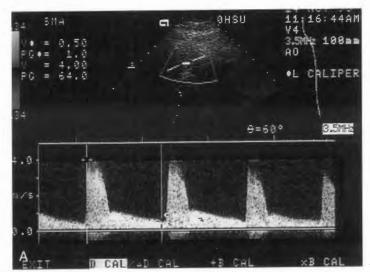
Duplex ultrasound velocity waveform (A) of the SMA origin, revealing a peak systolic velocity of 400 cm/s, suggesting the high-grade stenosis noted on a subsequent angiogram (B, arrow).
